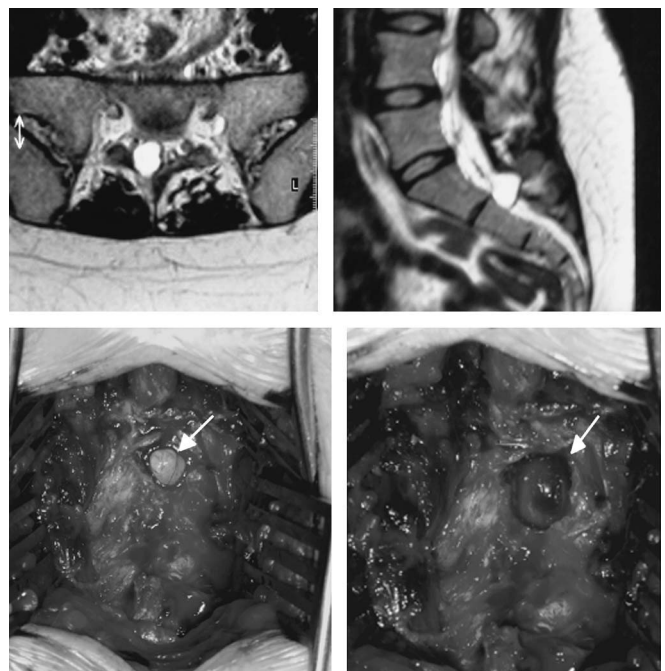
MRI and intraoperative images of a solitary Tarlov cyst at the right S2 level (arrows). The first intraoperative picture shows the local sacral erosion, the second the cyst once fully exposed.
